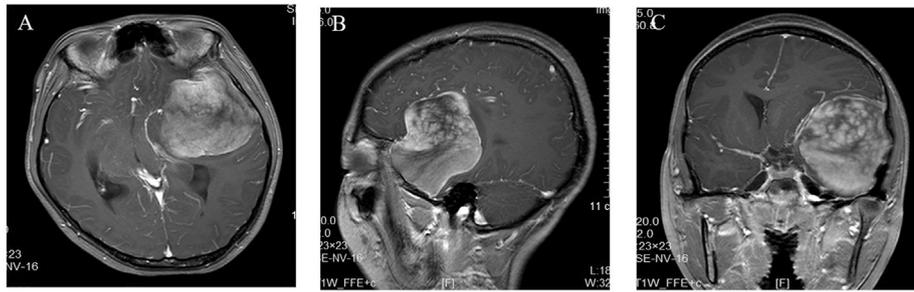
Preoperative neuroimaging findings of the intracranial dura-based mass. (A) T1-weighted axial MRI demonstrated a large heterogeneous gadolinium-enhanced mass in the left middle cranial fossa. The mass was dura-based and the attached dura also showed heterogeneous enhancement. (B) On T1-weighted sagittal image, the solid mass showed heterogeneous enhancement and was observed to invade the left infratemporal fossa. (C) On T1-weighted coronal image, the mass compressed the left frontal and temporal lobes, and shifted the middle line to the opposite side.
